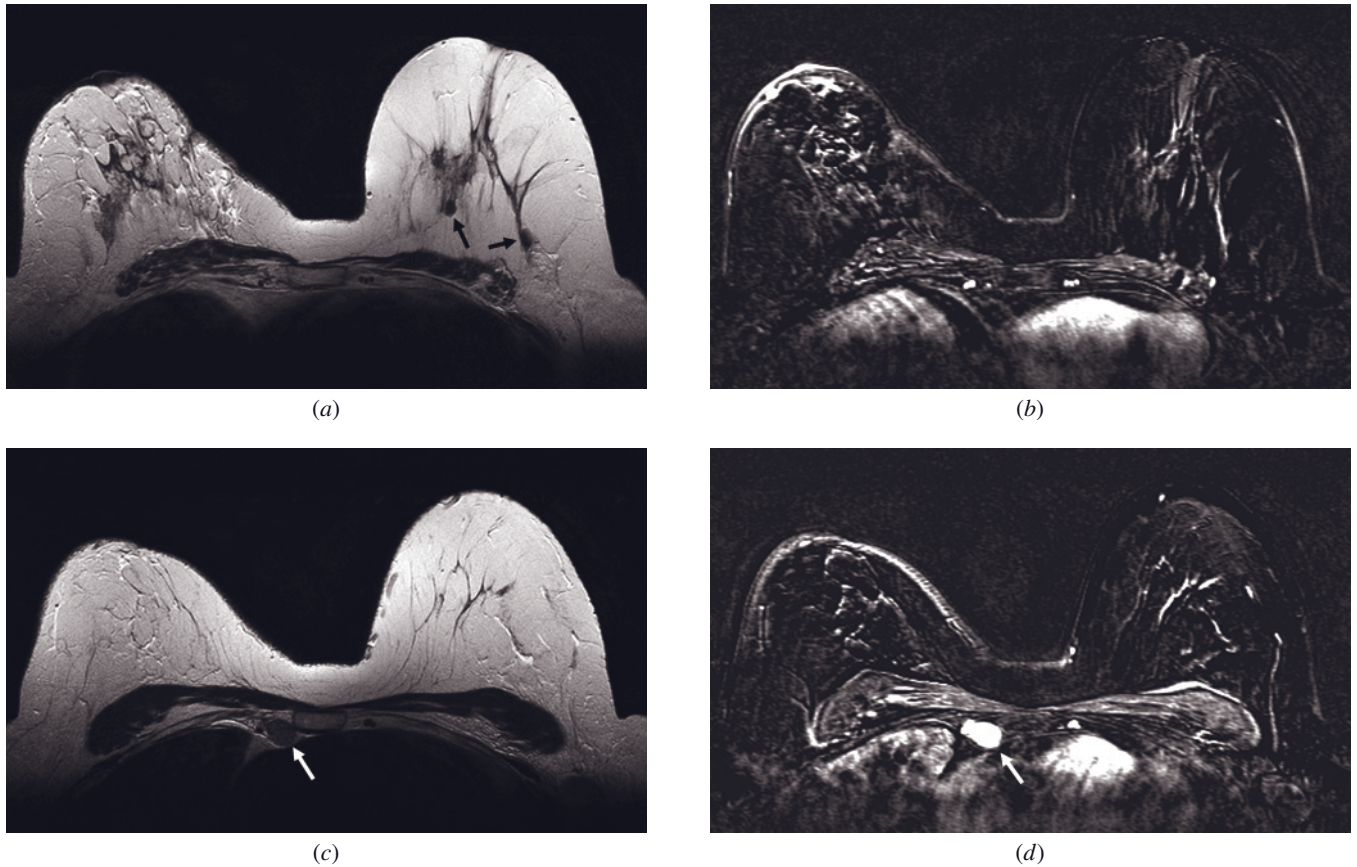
Breast MRI after BCT. Breast MRI after BCT most commonly reveals fibrosis, scar tissue, skin thickening, and lymphedema, as shown on axial T2-weighted (*a*) and subtracted (*b*) images without residual cancer. However, enlarged parasternal lymph nodes (white arrows) are seen (*c*, *d*), necessitating restaging. Note 2 small T2-weighted hypointense oval masses (*a*) with no postcontrast enhancement (*b*) in the right breast corresponding to hyalinized fibroadenomas (black arrows, *a*).
